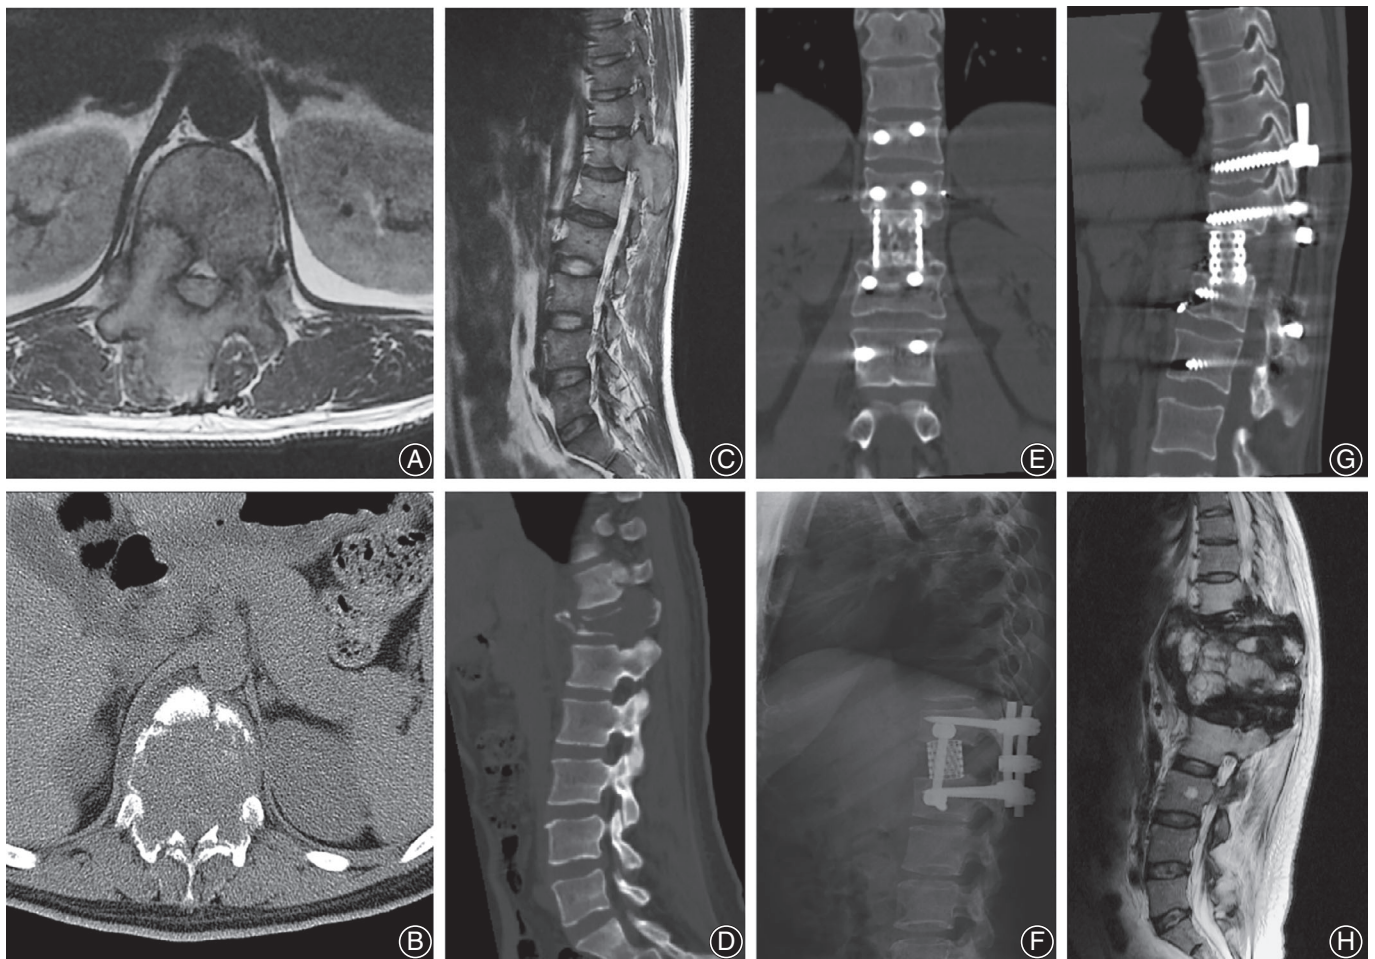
Top panel: A 35-year-old man, sagittal (A) and axial (B) MR images showed a mass on the T₁₂ vertebra, bilateral pedicle and lamina with extension into the spinal canal, maximum diameter of lesion is 42 mm, managed with *en bloc* resection (C), at a 36-month follow-up review, there was no evidence of recurrence (D). Bottom panel: A 35-year-old woman, sagittal CT images showed maximum diameter of lesion is 55 mm (E), with pathologic fracture of the T₁₂ vertebra (F), managed with *en bloc* resection (G), sagittal MR image showed tumor of both vertebral body and posterior element of T₁₂. The sagittal T2-weighted MR image at 12-month follow-up, recurrence was detected (H), and confirmed by pathology with puncture.
